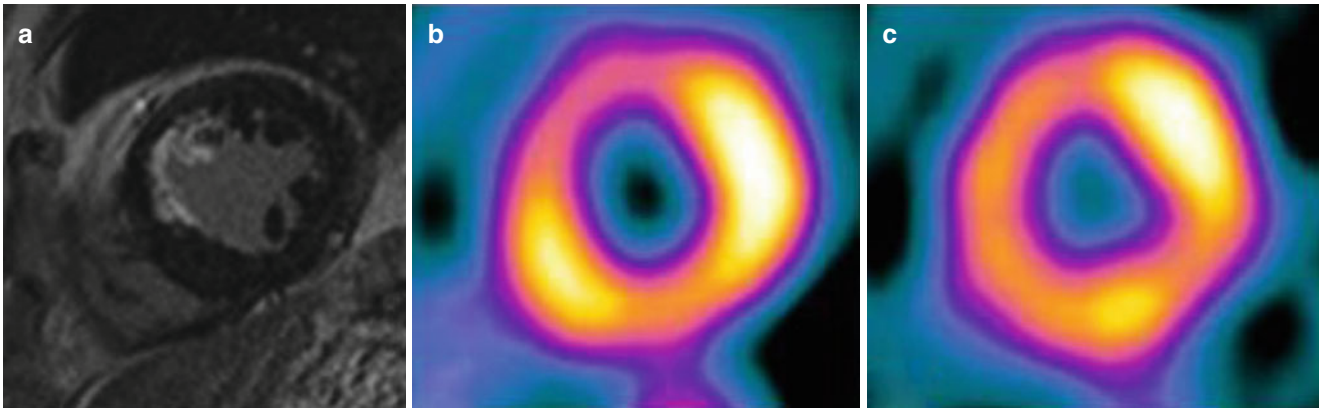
LGE comparison with SPECT for subendocardial infarction. MRI (a) shows subendocardial infarction at anteroseptal wall, but SPECT (b, c) shows reversible perfusion defect
